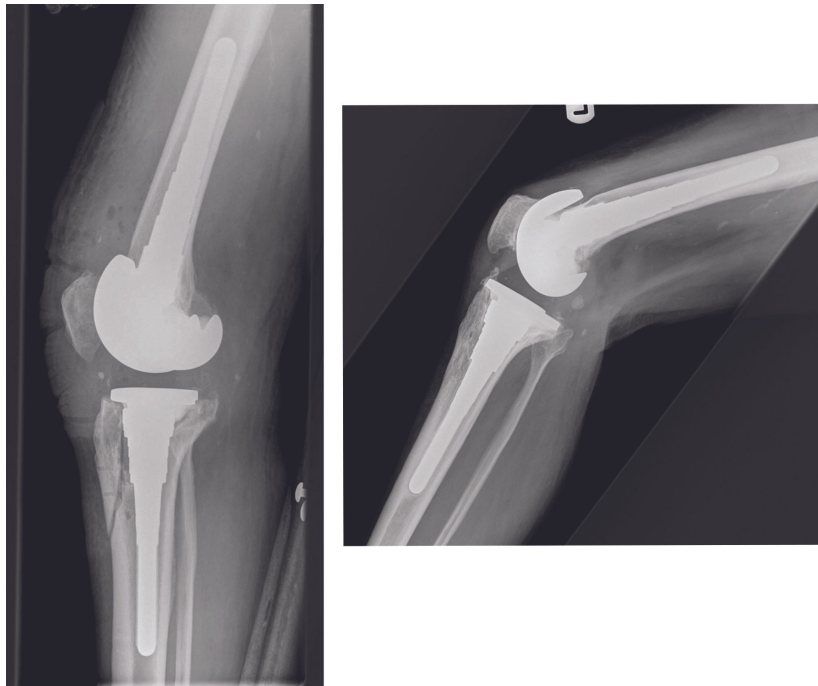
Immediate post-operative (left) and 3 months follow up radiographs (right) with the osteotomy united. Note the position of the drill holes in the top radiograph.
